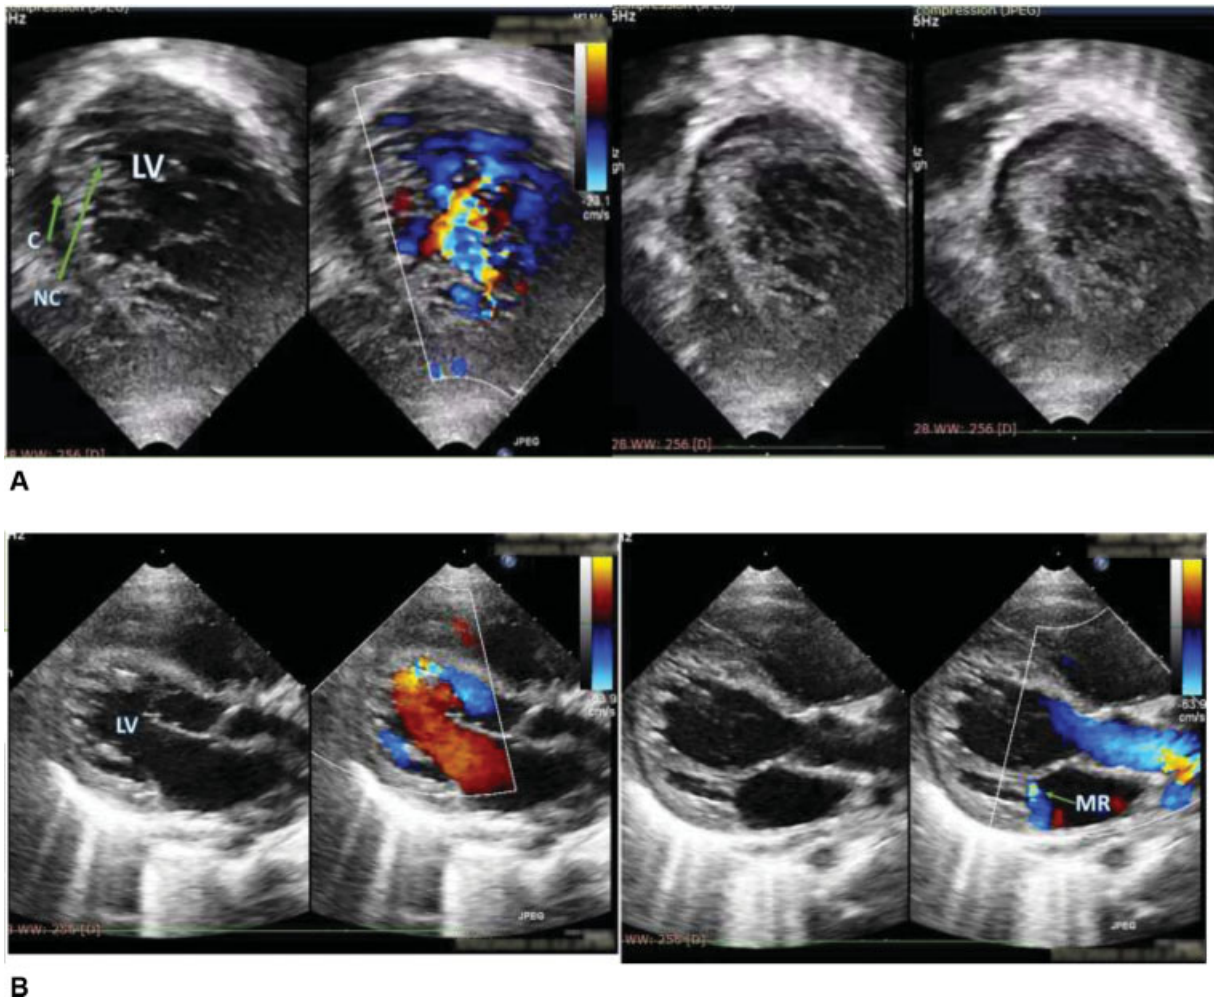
Parasternal short axis view; two-dimensional (2D), color Doppler image in diastole on the left shows compacted (C) and noncompacted (NC) region on the septum and free wall of the left ventricle (LV) with color flow in intertrabecular recesses; two systolic frames on the right are delineating the extent of noncompacted LV. Parasternal short axis view; 2D, color Doppler image in diastole on the left and systole on the right shows apical and free wall NC of LV with mild mitral regurgitation (MR).
